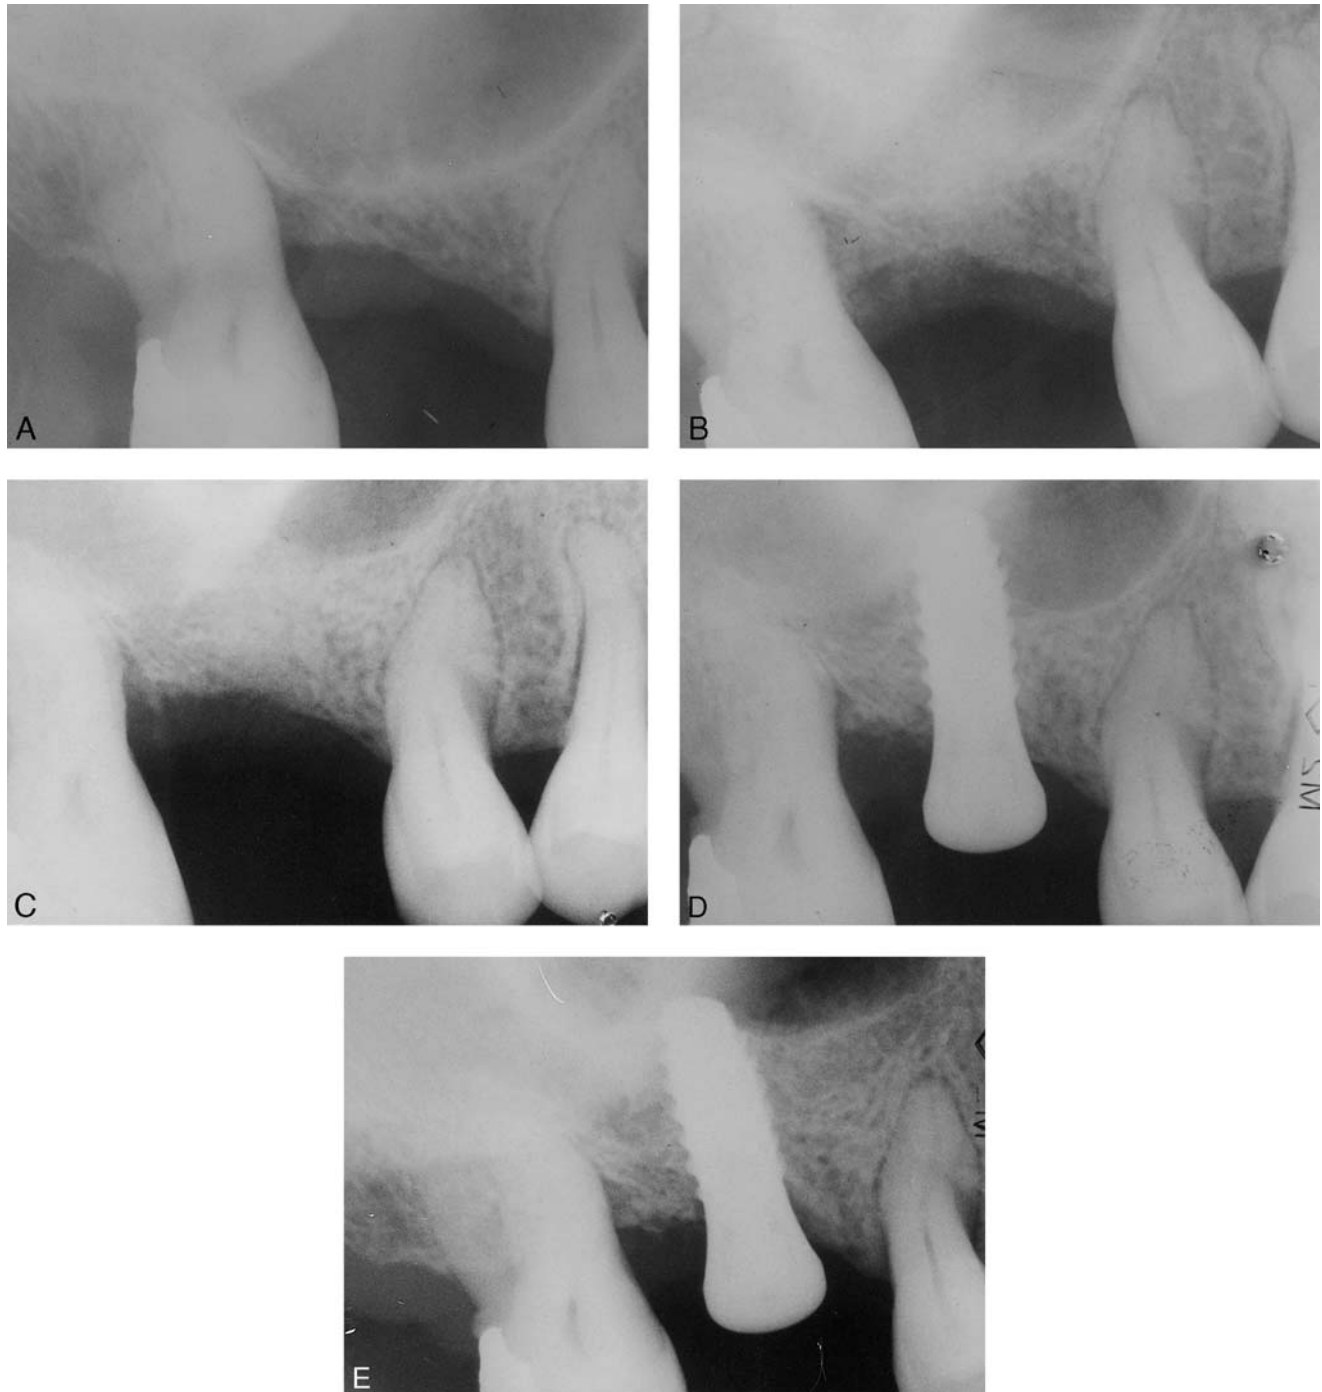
(A) Preoperative radiograph of the extracted site of #3. (B) Immediate postsurgical radiograph of the grafting site (first stage). Note the radio-opacity, representing the grafting materials within the sinuses. (C) Eight months after first-stage grafting. (D) Immediate radiograph after the second-stage grafting and implant placement. (E) Eight months after the second stage. Note the height of new bone, which has significantly increased and covered the entire length of the implant.
